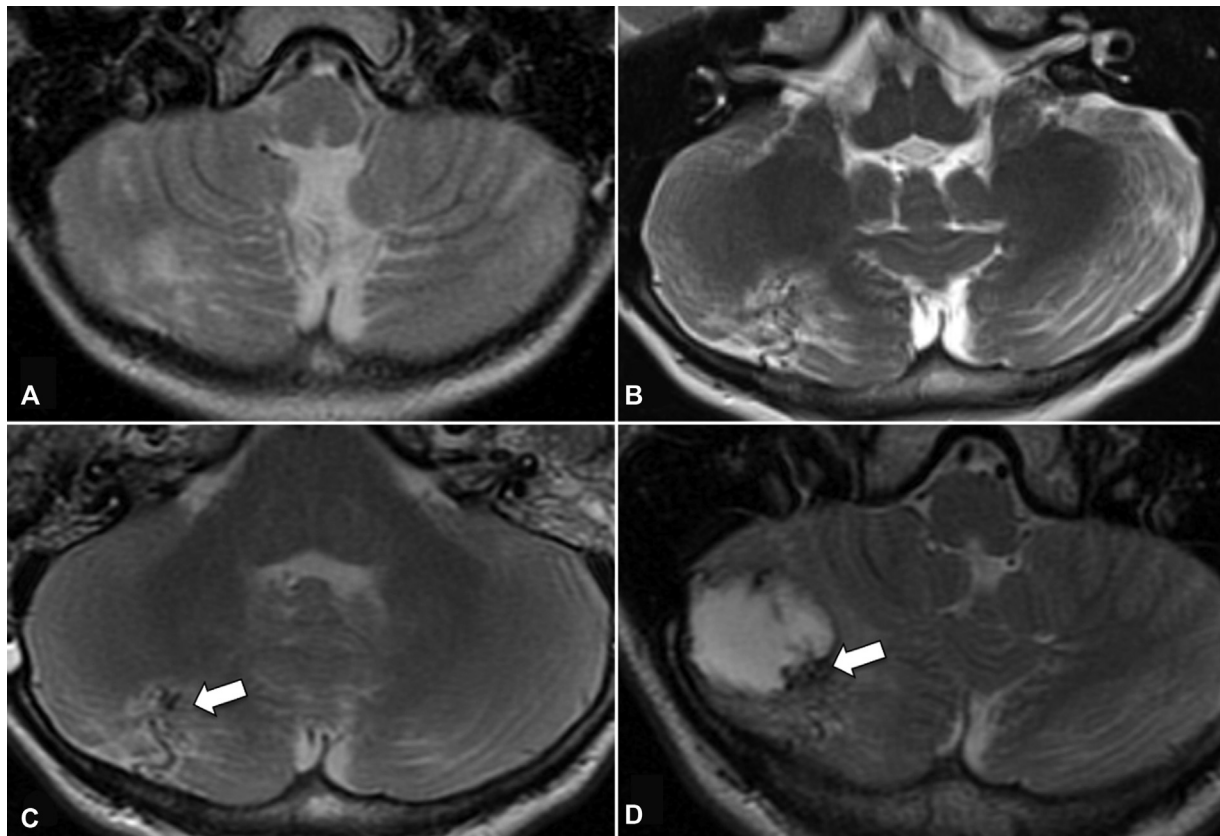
A 2-year-old male with tuberous sclerosis complex. (A) T2-weighted image (T2WI) shows a right-cerebellar tuber. (B) Seven years later, a flow void indicating an associated vascular anomaly (AVA) appears. (C) Nine years later, a nodular T2-hypointense focus within the tuber develops (arrow). (D) Eleven years after the initial scan, T2WI and T1-weighted image (T1WI) (not shown) demonstrate parenchymal hemorrhage occurring adjacent to the region of the previously imaged associated vascular anomaly and the T2-hypointense focus (arrow)
